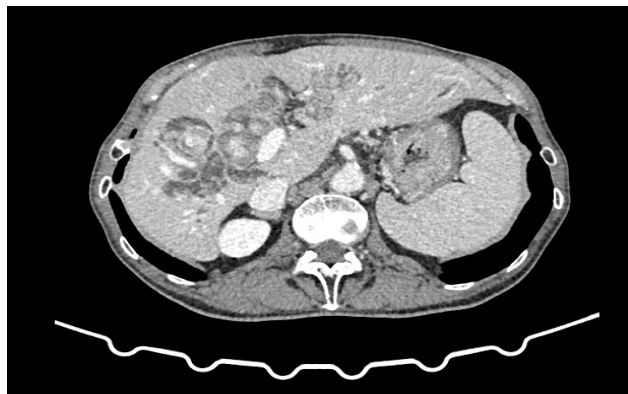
Computed tomography abdomen and pelvis imaging at time of presentation (axial view), demonstrating multiple solid echogenic lesions in liver parenchyma correspond to multiple intrahepatic duct stones.
